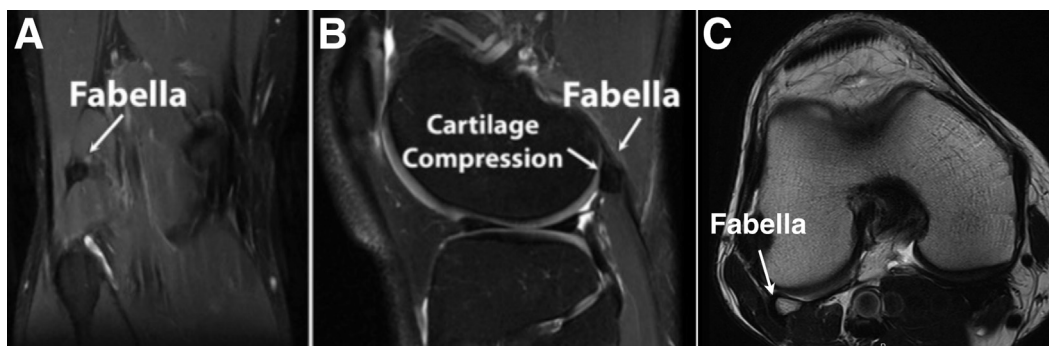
Magnetic resonance imaging (MRI) of a right knee reveals the relationship between the fabella with the lateral femoral condyle and the gastrocnemius tendon in the coronal (A), sagittal (B), and axial (C) views. After a clinical assessment with physical examination, MRI is used to evaluate localized osteoarthritis, cartilage softening and periosteal inflammation of the fabella and femoral condyle.
